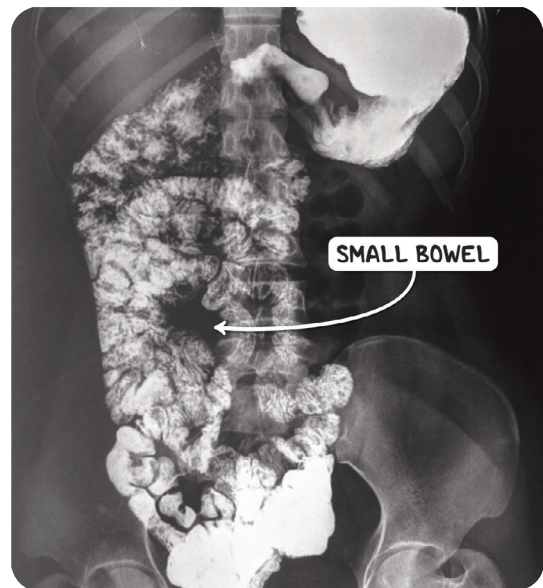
An abdominal X-ray with bowel contrast demonstrating intestinal malrotation. The entire small bowel is situated on the right side of the abdomen.
